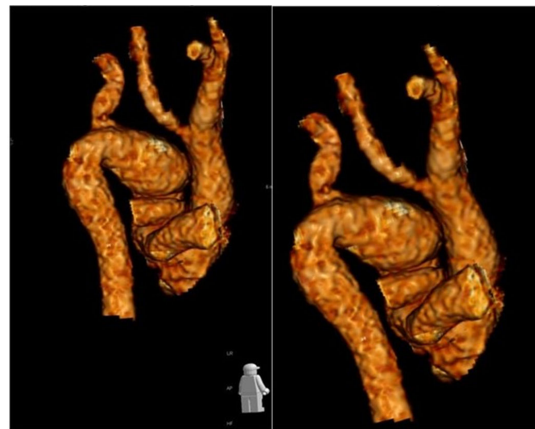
3D reconstruction of CT Angiogram from posterior aspect, showing truncal root, criss-crossing of PA's, Type B interrupted aortic arch with ascending aorta giving rise to Right Brachio-Cephalic Artery, Left Common Carotid Artery, and ductal arch connecting to descending aorta which gives rise to Left Subclavian artery.
